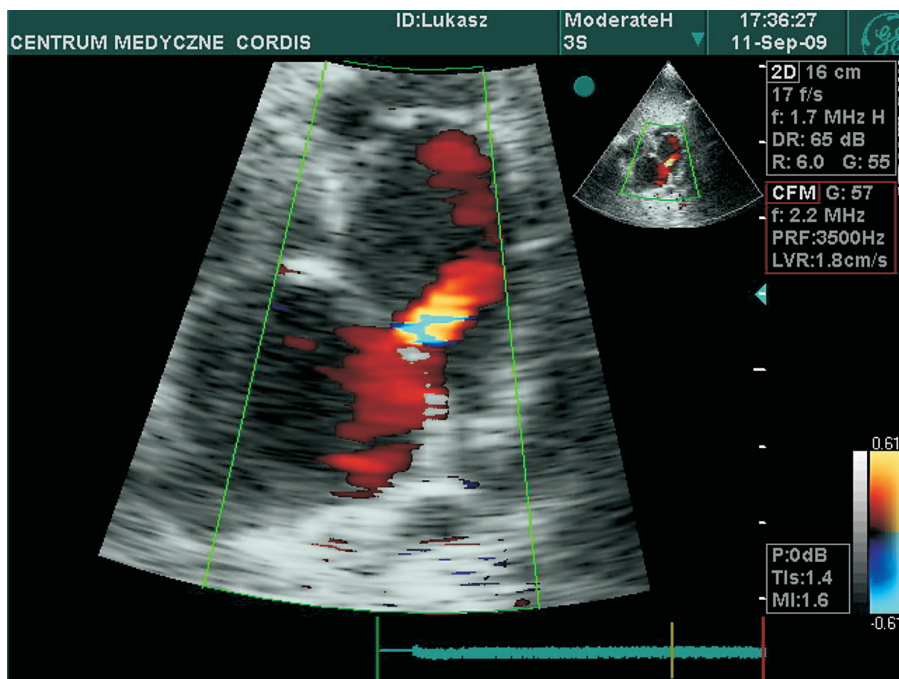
Echocardiography. Ostium secundum atrial septal defect (ASDII)
